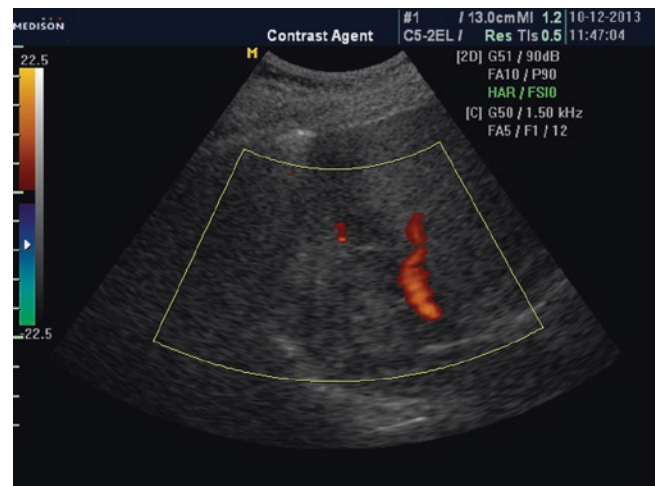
Intrahepatic cholangiocarcinoma, Doppler interrogation
